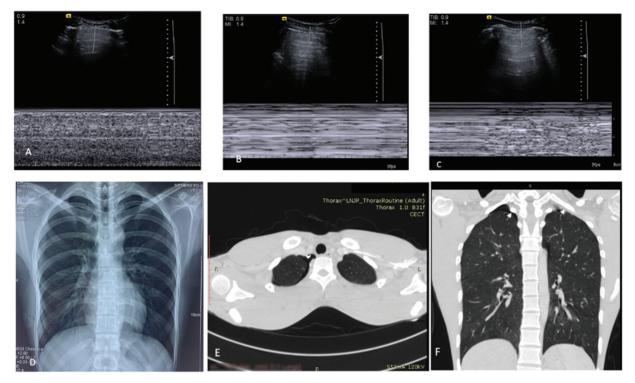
(A-C): Longitudinal ultrasound scans performed in a 21-year-old, tall lean male patient who presented with acute dyspnea and chest pain revealed (A) A-lines, no B-lines with maintained lung sliding seen as Sea-shore sign on M-mode tracing in the anterior chest. (B) Absence of lung sliding with Stratosphere sign was localized at right lateral upper chest wall in mid-axillary line. (C) The lung point was demonstrated medially between the anterior axillary line and mid clavicular line, representing a small pneumothorax. (D) Chest X-ray in the same patient was reported as normal with no evidence of pneumothorax (D) CECT Chest subsequently revealed a small pneumothorax tracking along apical segment of right upper lobe (arrow head) in axial scans. (E) Subcentimetric cysts (F) were also noted in apical segments of bilateral upper lobes in the coronal scan, confirming the diagnosis of spontaneous pneumothorax as made on ultrasound which was radiographically occult.
